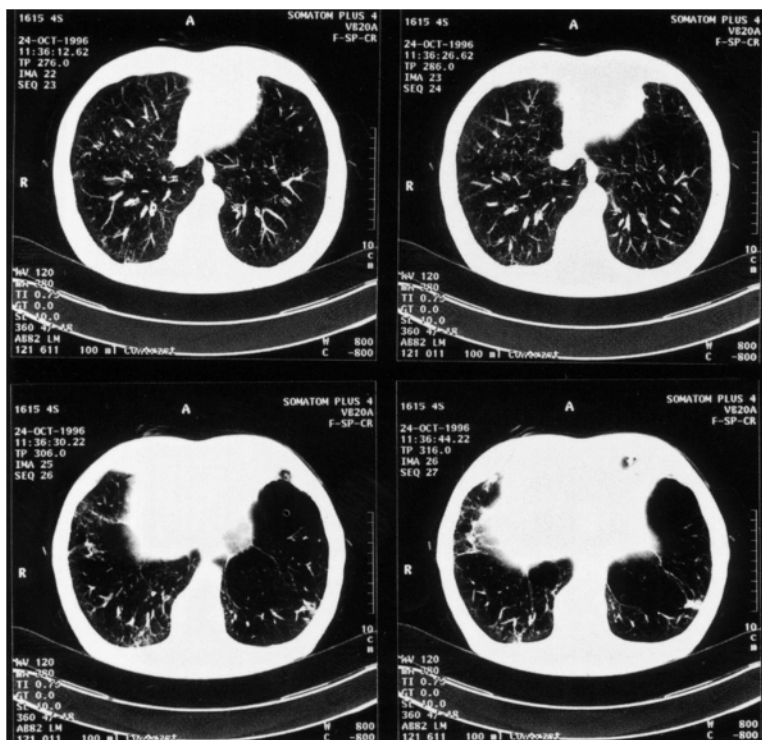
CT scans at the lower levels show advanced pulmonary emphysema
